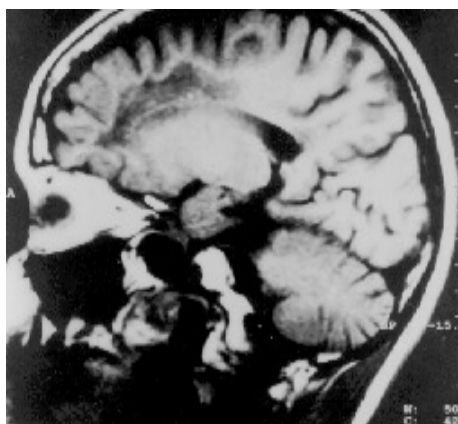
Case No1. A T1 dependent MRI-CT image of the vertical cross-section. Around the cornua of lateral ventricles – irregular hypodensive areas corresponding with demyelination foci are seen.
